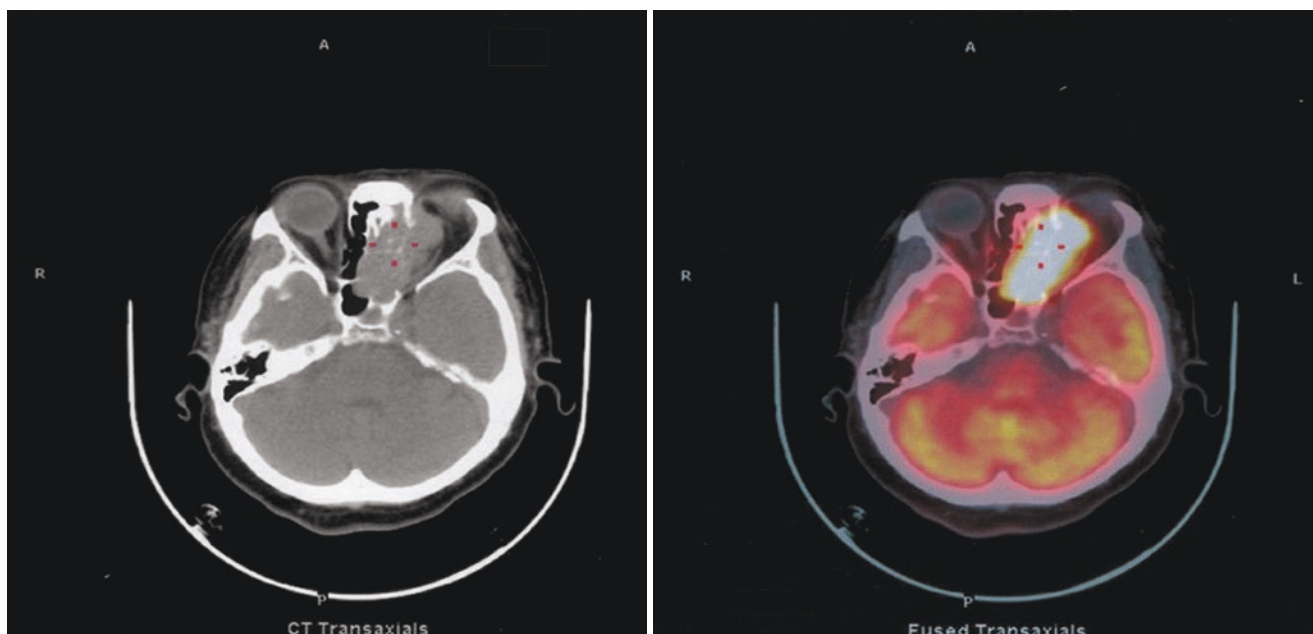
PET/CT shows that the soft tissue-occupying lesion with elevated metabolic activity in left nasopharynx apex has penetrated into the eye, SUVmax36. The pathological diagnosis was Nk/t cell lymphoma outside nasal nodules
